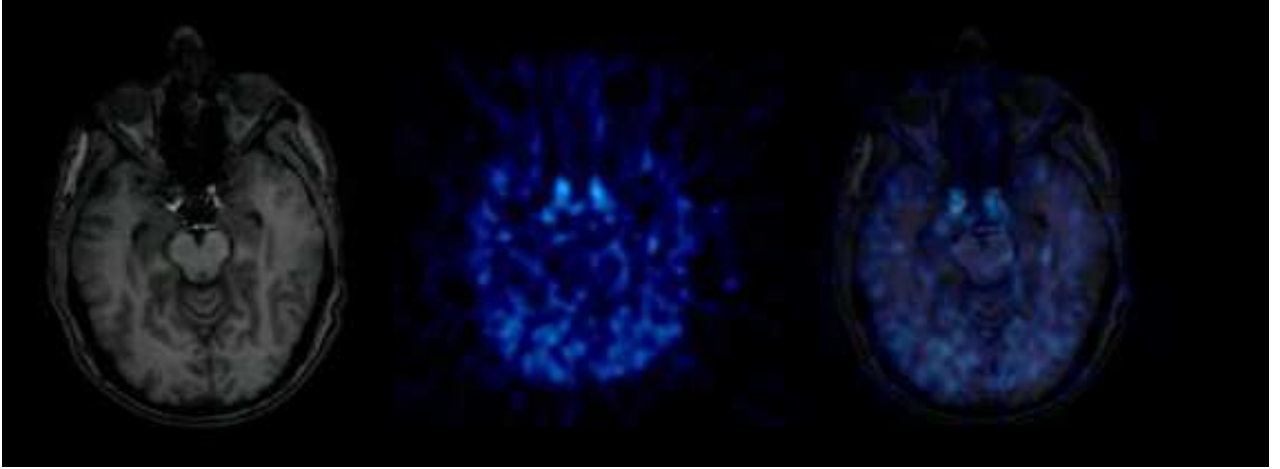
a. Left: MRI scan showing the carotid arteries Center: PET image summed for first 40 seconds. Right: Coregistered PET-MR image
